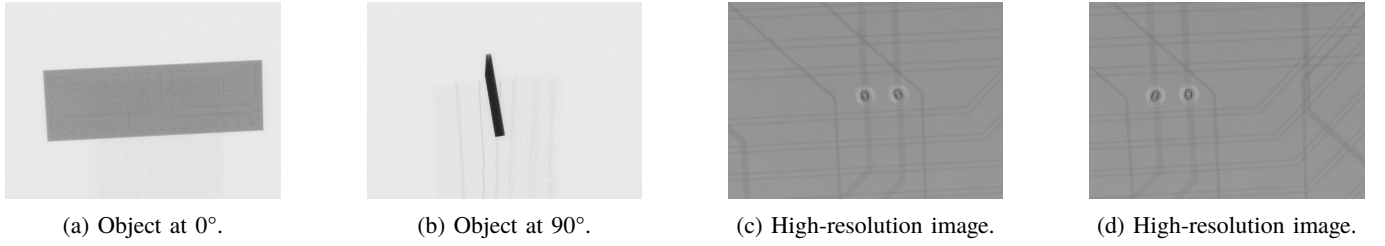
(a) and (b): Images for normal CT, (c) and (d): high-resolution 2D images.
